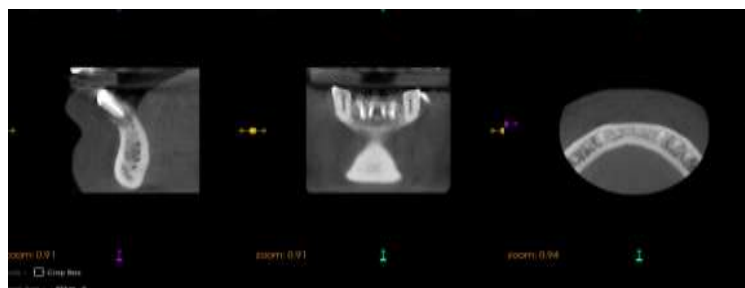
CBCT after 9 months
